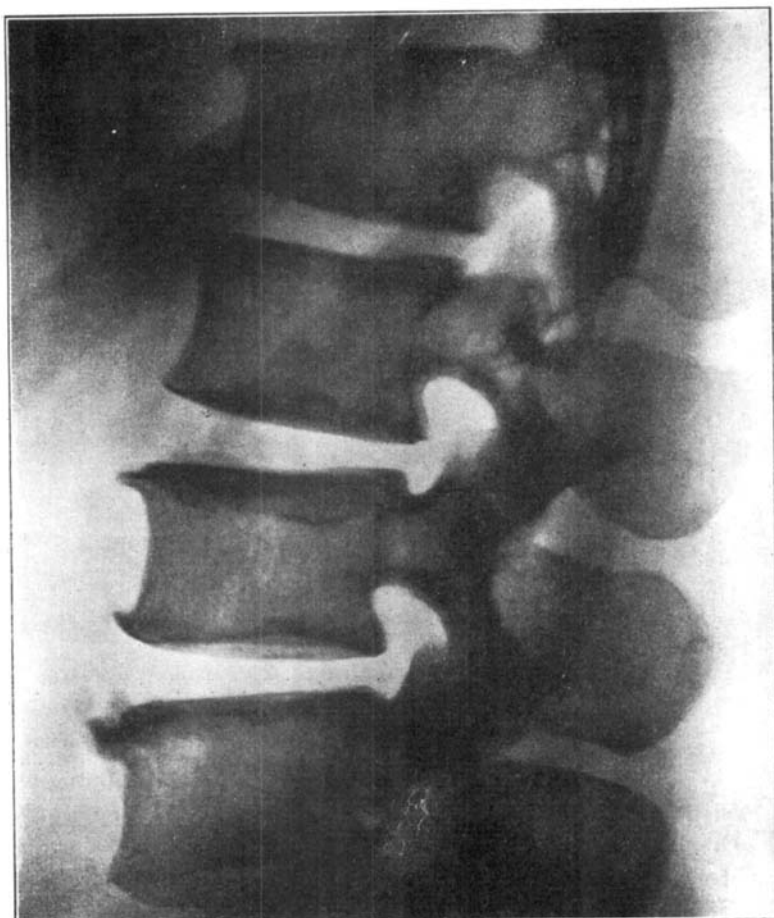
Roentgenogram showing details of lumbar spine. Spondylosis deformans.
